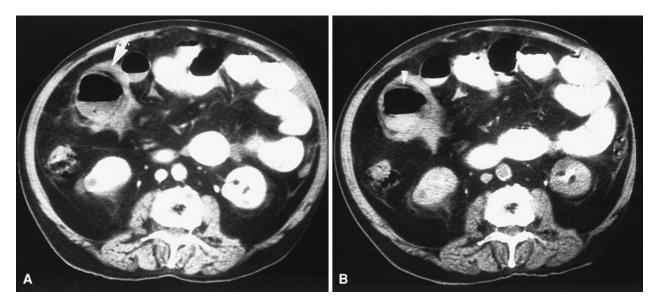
Case 2. A 69-year-old man with acute Meckel's diverticulitis. A Contrast-enhanced CT demonstrates an air–fluid collection in the right mid-abdomen adjacent to small bowel loops (*arrow*), surrounded by strands indicating inflammatory changes. The proximal small bowel is
